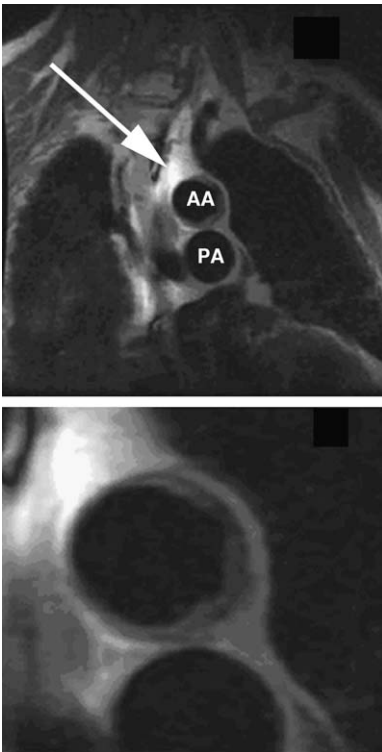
Double IR FSE proton-density images of the aortic arch, in a patient with advanced atherosclerosis, obtained using a combination of surface and transesophageal MR imaging, demonstrating excellent delineation of the atherosclerotic plaque. The arrow points to the hyperintense signal related to the transesophageal receiver coil. AA, aortic arch; PA, pulmonary artery.
